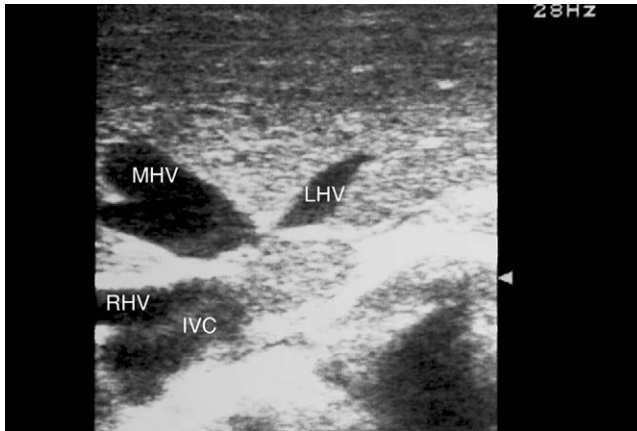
Ultrasonographic view of the confluence of the right (*RHV*), middle (*MHV*), and left (*LHV*) hepatic veins with the inferior vena cava (*IVC*).
